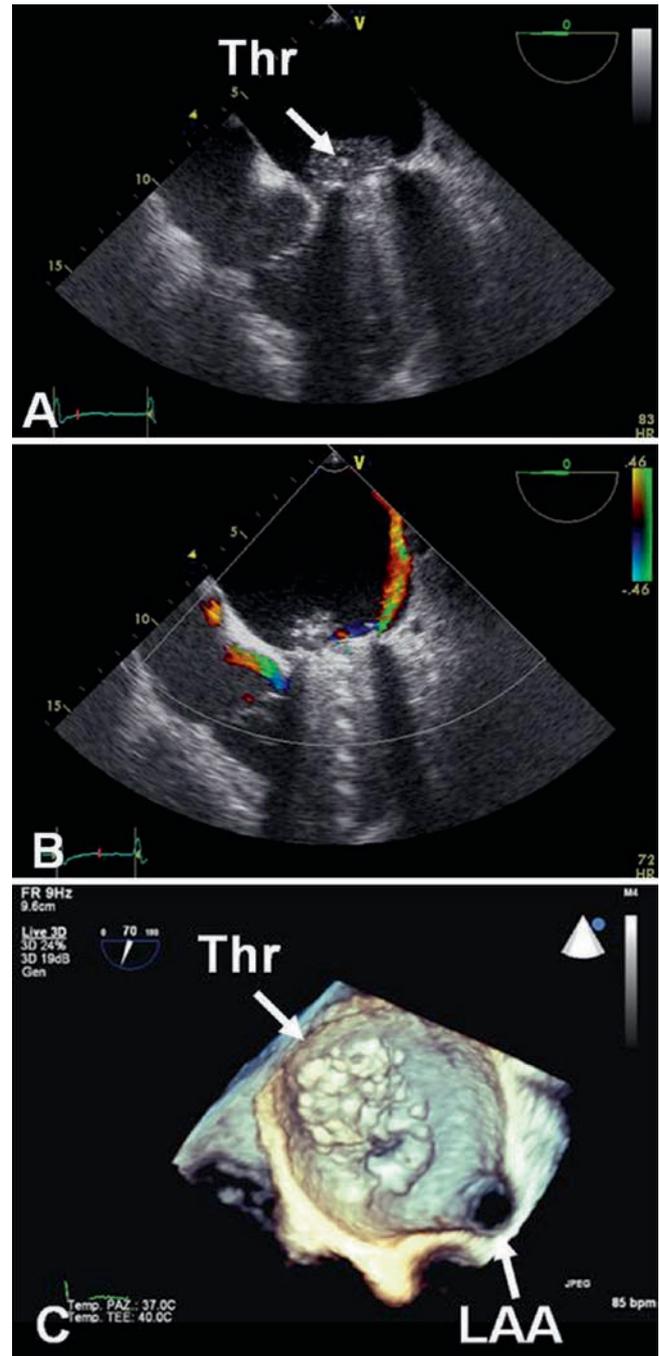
Massive thrombosis on the atrial side of a bileaflet-tilting-disc valve in the mitral position (*white arrow*), (a) at trans-oesophageal. The presence of thrombus usually holds it in a semi-open position that creates an eccentric intra-prosthetic regurgitation (b). Real-time 3D trans-oesophageal echocardiography offers a better assessment of the extension and dimensions of the Thr, thrombus, LAA, left atrial appendix(c)
